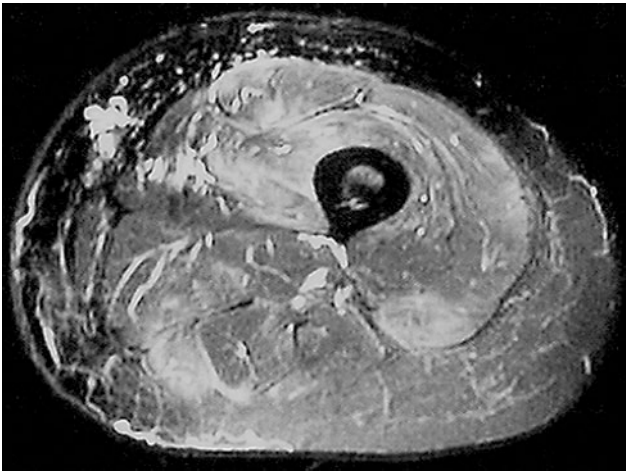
MRI of thigh using a fat-suppressed T2-weighted short tau inversion recovery sequence demonstrates increased edema-like signal in the muscle of this woman with polymyositis (modified from Weber et al. (2007))
